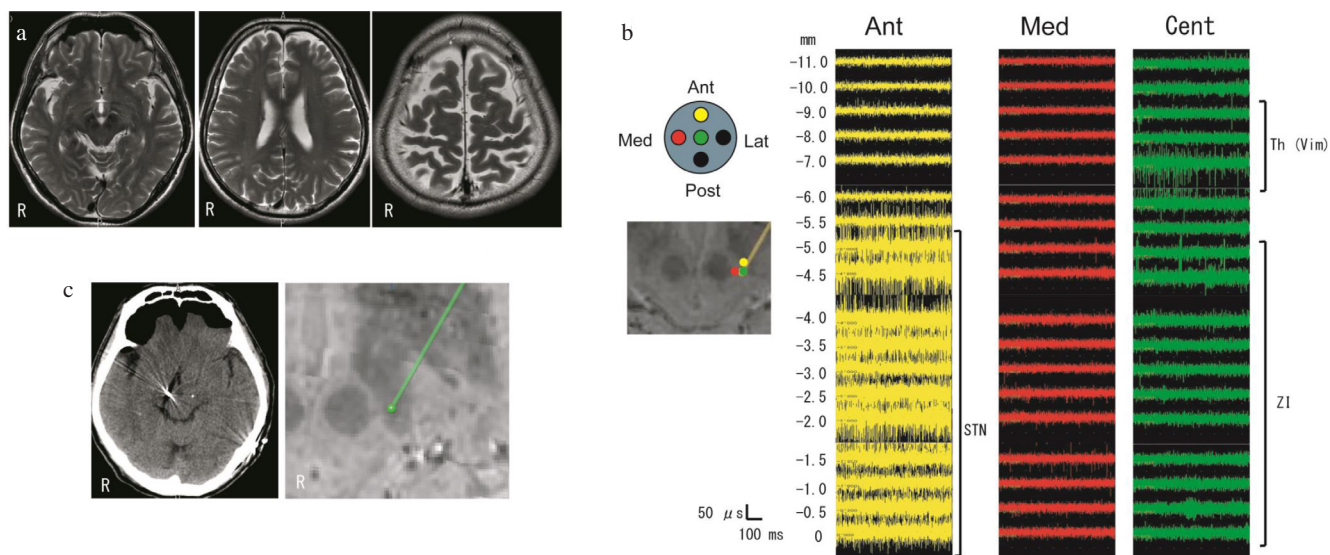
(a) Preoperative MRI revealed mild brain atrophy. (b) The location of tips of central, anterior, and medial electrodes. The central, anterior, and medial electrodes are supposed to be inserted within cZI, pSTN, and Raprl respectively. The microelectrode recording of each electrode. At 7–9 mm above the target, thalamic activity was recorded from the central electrodes. At 5 mm above the target, STN activity was recorded from the anterior electrode. (c) Postoperative CT and preoperative MRI fused with postoperative CT. Postoperative CT showed pneumocephalus. Preoperative MRI fused with postoperative CT revealed that the left electrode was placed in the posterior STN. Ant: anterior, Cent: central, Lat: lateral, Med: medial, Post: posterior, STN: subthalamic nucleus, Th: thalamus, Vim: ventral intermediate nucleus, ZI: zona incerta.
